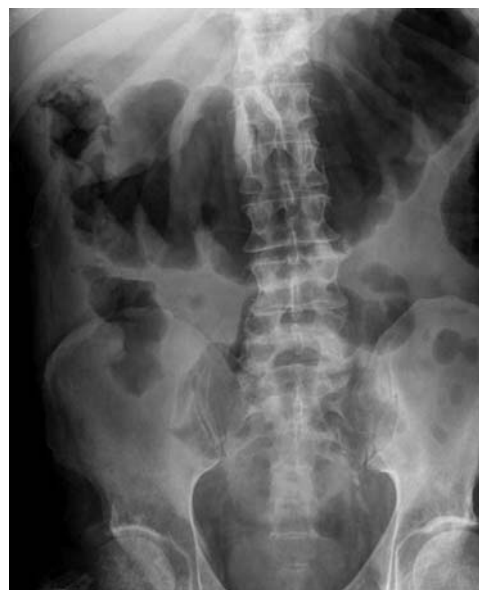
Plain film of toxic megacolon demonstrating dilated transverse colon.
